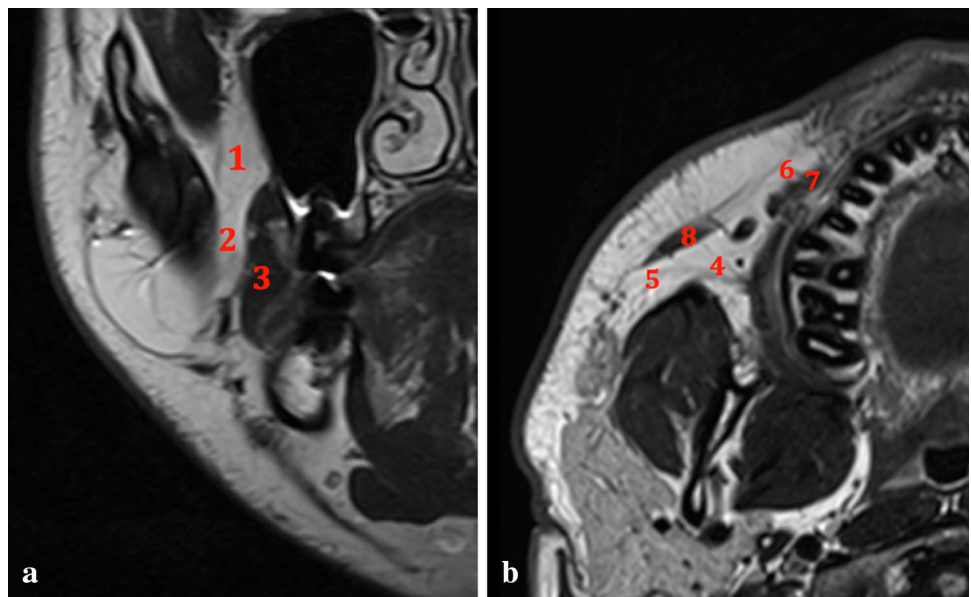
a, b Cropped coronal (a) and axial (b) slices of T2-weighted MRI, showing the buccal extension of the MFP and its anterior prolongation. 1 Body of MFP, 2 buccal process of MFP, 3 buccinator muscle, 4 buccal fat pad, 5 posterior extension of buccal fat pad, 6 anterior extension of buccal fat pad, 7 levator anguli oris muscle, 8 zygomaticus major muscle
